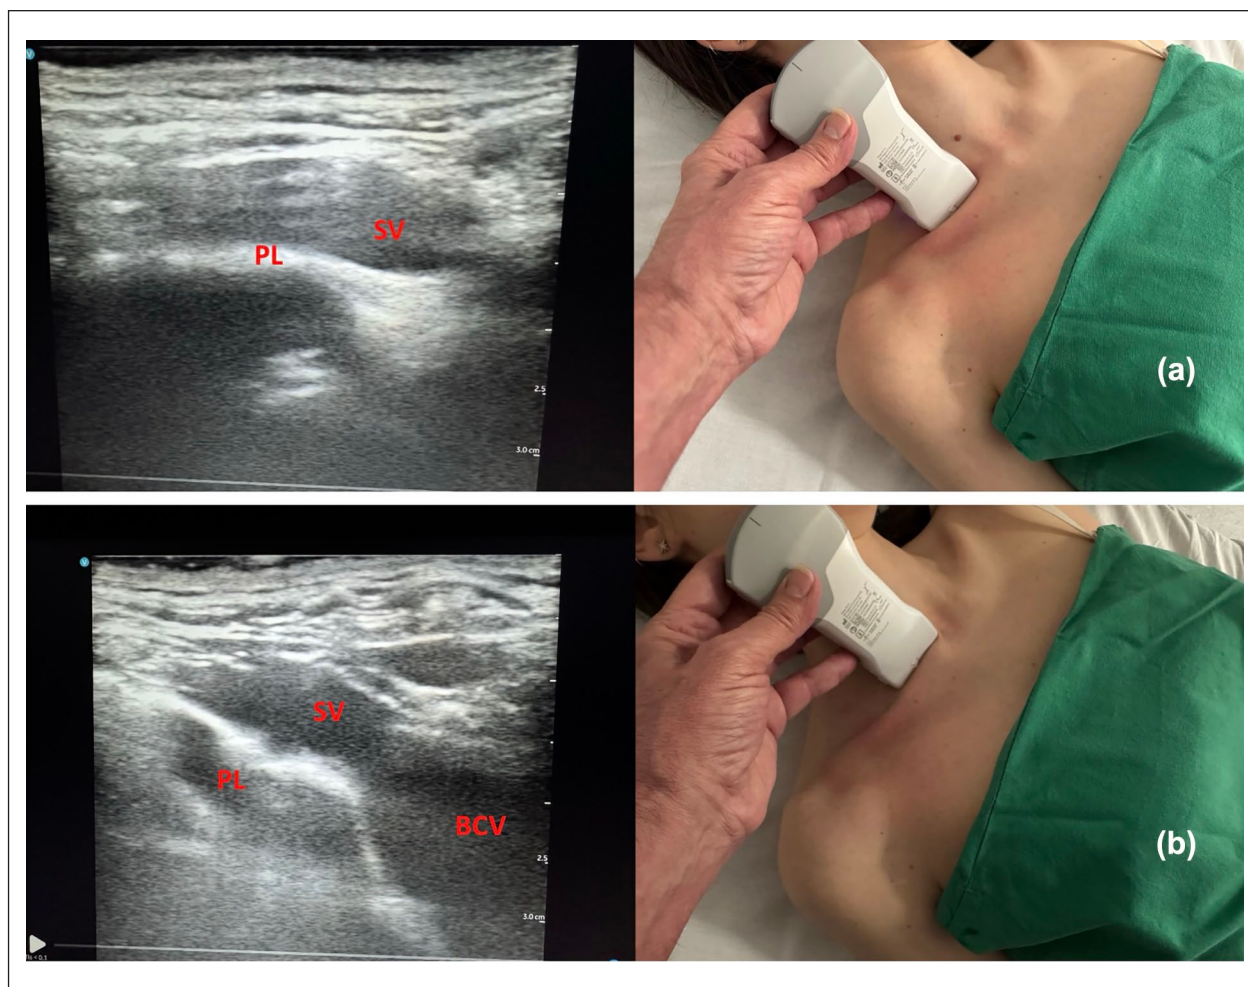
Ultrasound visualization of the subclavian vein in the supraclavicular area, in long axis, behind the middle third of the clavicle (a) and behind the medial third of the clavicle (b).
